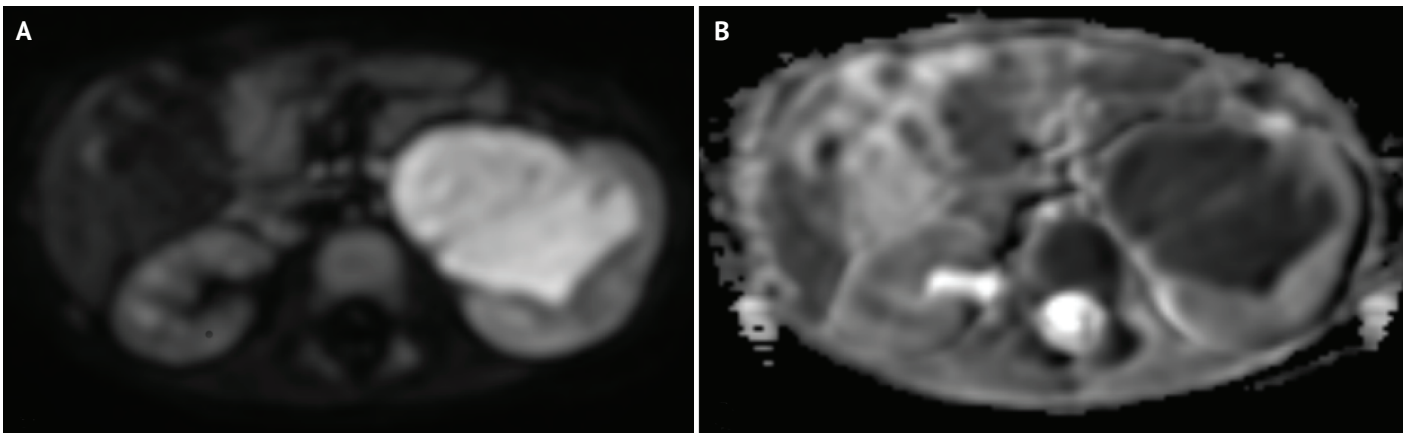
(A) Diffusion-weighted imaging (DWI) (b=800), (B) Apparent diffusion coefficient (ADC).
